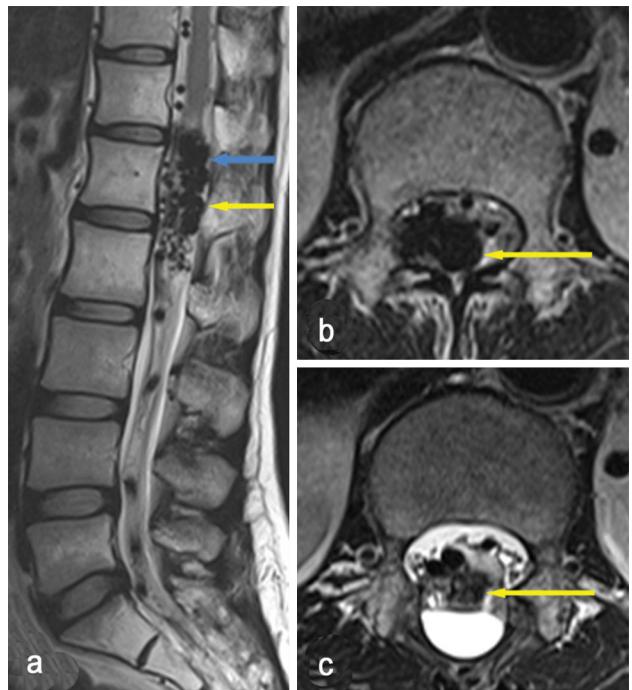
Preoperative sagittal and axial MRI images are shown in parts a and b. The fistular component and AVM are indicated by yellow and blue arrows, respectively. A signal change and decreased size in the glue embolized fistular sac is evident by postoperative MRI 2 months later (c)
